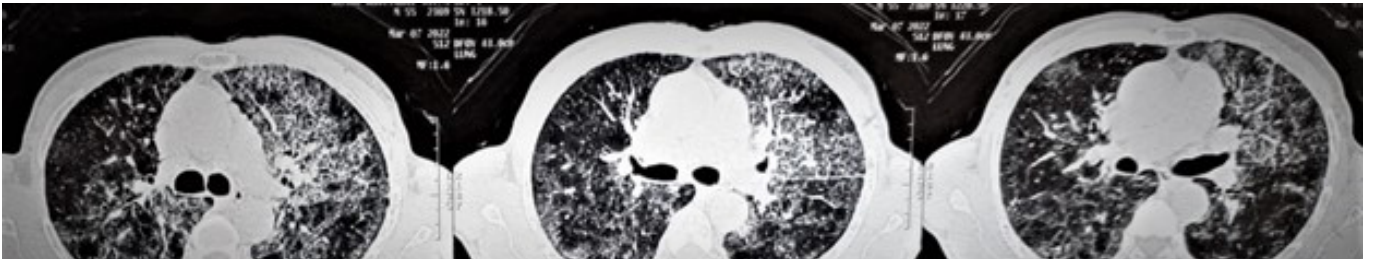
Initial High Resolution Computed Tomography of chest of the patient demonstrating the crazy waving pattern with smooth thickening of the interlobular septa along with ground glass opacity.
